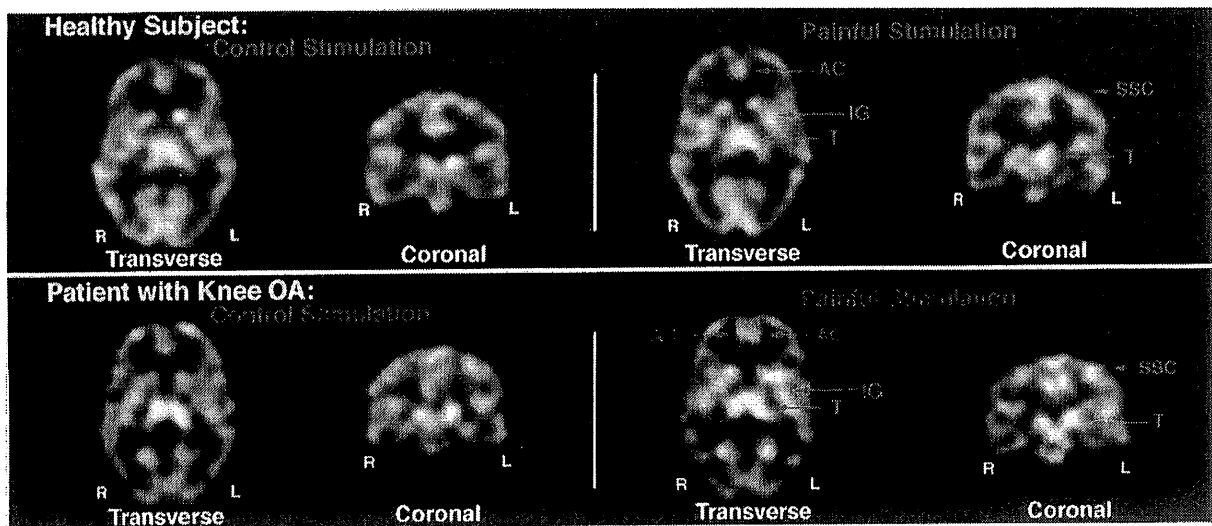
Xenon¹³³ SPECT brain imaging showing brain responses to low intensity pressure stimulus (Control Stimulation) and a painful stimulus (Painful Stimulation) of a healthy subject (top panel) and a patient with knee OA (bottom panel), both delivered to the right knee. The low intensity stimulus was set at 1 kg for both participants. The painful stimulus was set at 4 kg above the pain threshold level of the participant. For the healthy participant, in comparison with the low intensity stimulus, painful stimulation produced a small increase in activation of the left thalamic region (T) and left somatosensory cortex (SSC), a moderate increase in activation of the left insular gyrus (IG), and minimal activation of the anterior cingulate area (AC). In contrast, for the patient with OA, painful stimulation produced a modest increase in activation of the left thalamus (T) and moderate to large increases in activation of the left and right anterior cingulate cortices (AC), left somatosensory cortex (SSC), and left insular gyrus (IG). All findings of this preliminary analysis, with the exception of those concerning activation of the insular gyrus, were presented in Reference 1.
